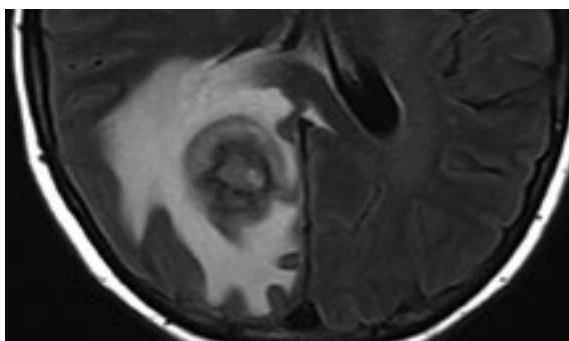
MRI scan of the brain revealed a solitary 2.4 cm peripherally enhancing right parietal lobe lesion with centrally restricted diffusion and significant adjacent vasogenic edema and local mass effect.
